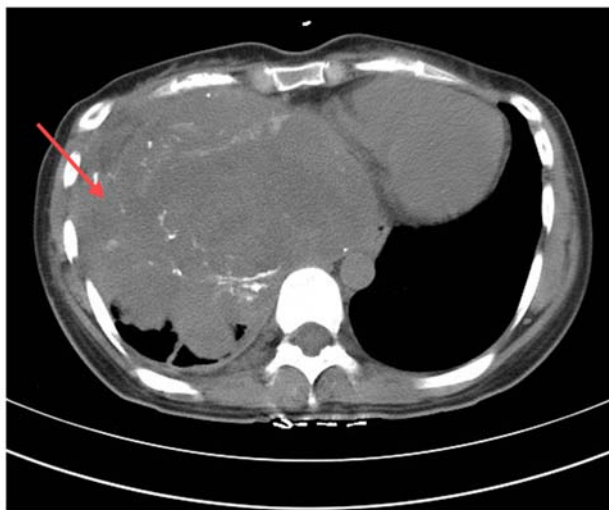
Computed tomography image at the 5-year follow-up suggesting a right-sided thoracic mass (red arrow).
